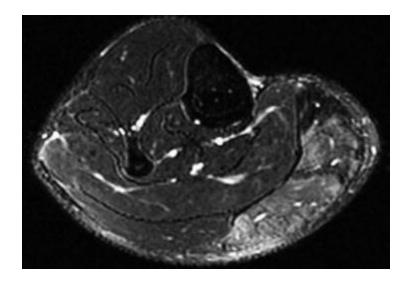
Neurogenic muscle hypertrophy associated with an S1 radiculopathy due to a disk herniation (From Zabel et al. [49]). Axial fat-suppressed T2-weighted MRI of the calf shows enlargement, edema and fatty degeneration of the medial gastrocnemius
